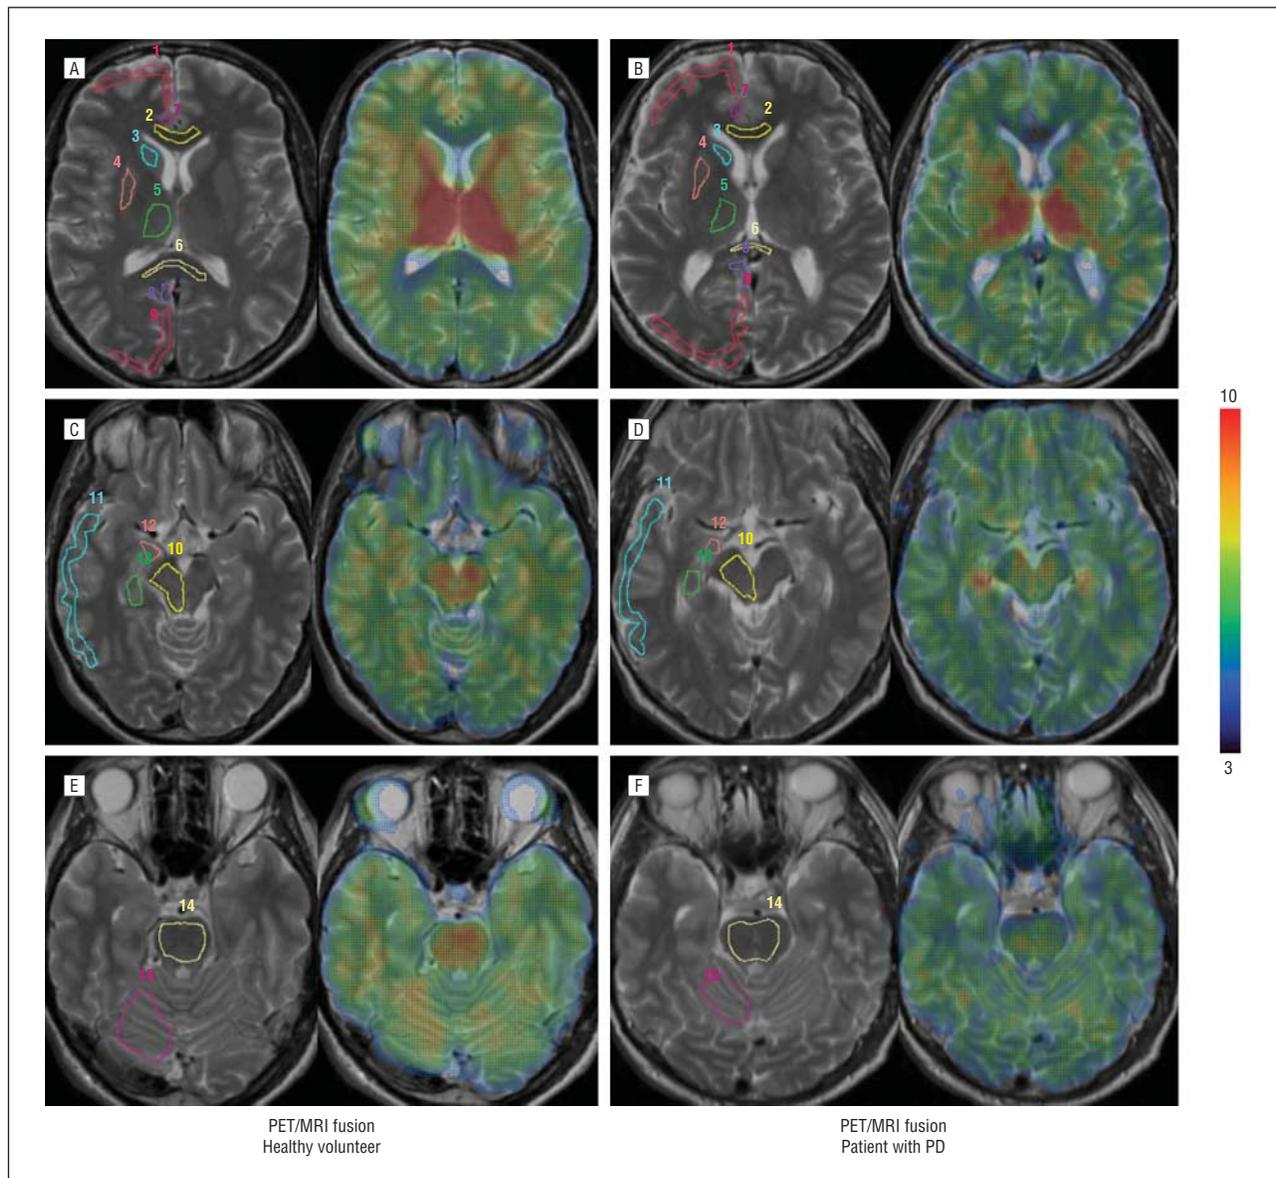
Transaxial sections of positron emission tomography (PET) and magnetic resonance imaging (MRI) 2- ^{18}F fluoro-3-(2[S]-2-azetidylmethoxy)-pyridine (2- ^{18}F FA-85380) distribution volume (2-FA DV) fusion images in a healthy volunteer (A, C, and E) and a patient with Parkinson disease (PD) (B, D, and F) demonstrate widespread cortical and subcortical reduction of 2-FA DV in the patient with PD compared with the healthy volunteer. The 2-FA DV values range from low (blue) to high (red) as indicated by the pseudocolored bar. Manually drawn regions of interest for data analysis are shown in the ipsilateral side of the brain in 3 exemplary transaxial sections of individual MRIs in a healthy volunteer and a patient with PD. Regions of interest are labeled with numbers, and anatomical locales are assigned as follows: 1, frontal lobe; 2, corpus callosum (genu); 3, caudate nucleus; 4, putamen; 5, thalamus; 6, corpus callosum (splenium); 7, anterior cingulate cortex; 8, posterior cingulate cortex; 9, occipital lobe; 10, midbrain; 11, temporal lobe; 12, amygdala; 13, hippocampus; 14, pons; and 15, cerebellum. Regions of interest in the parietal lobe are not shown.
